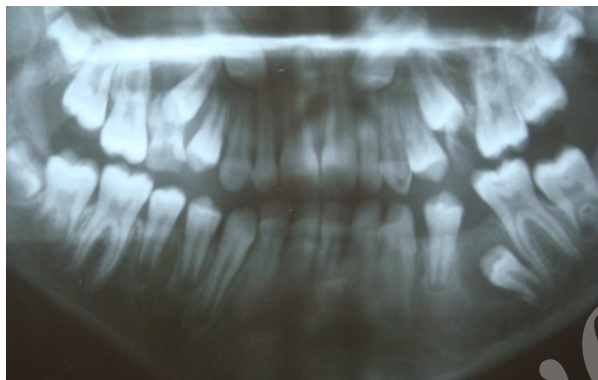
Panoramic radiograph taken 12 months after extraction of mandibular left primary second molar
